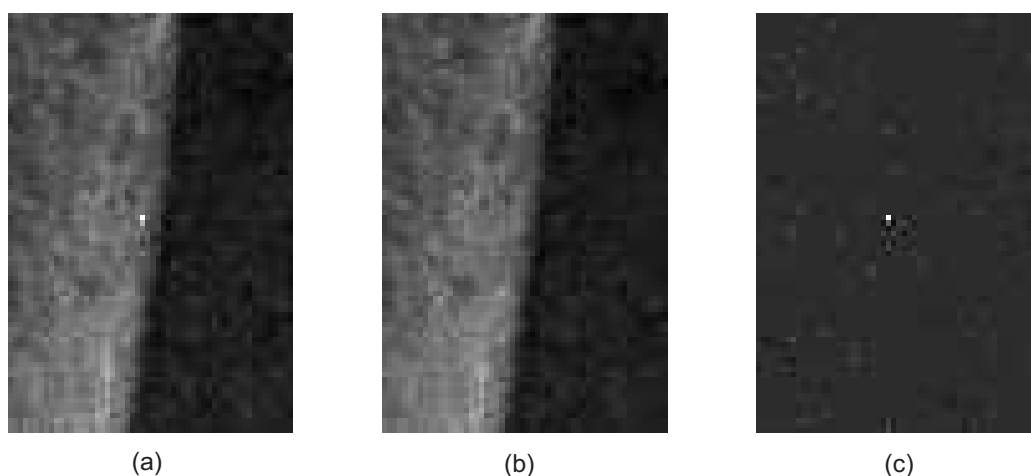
Single-pixel impulse noise removed using the MAD-based outlier filter. (a) original radiograph; (b) denoised image; (c) method noise. Note the minimal impact of the outlier detector on the image noise.
